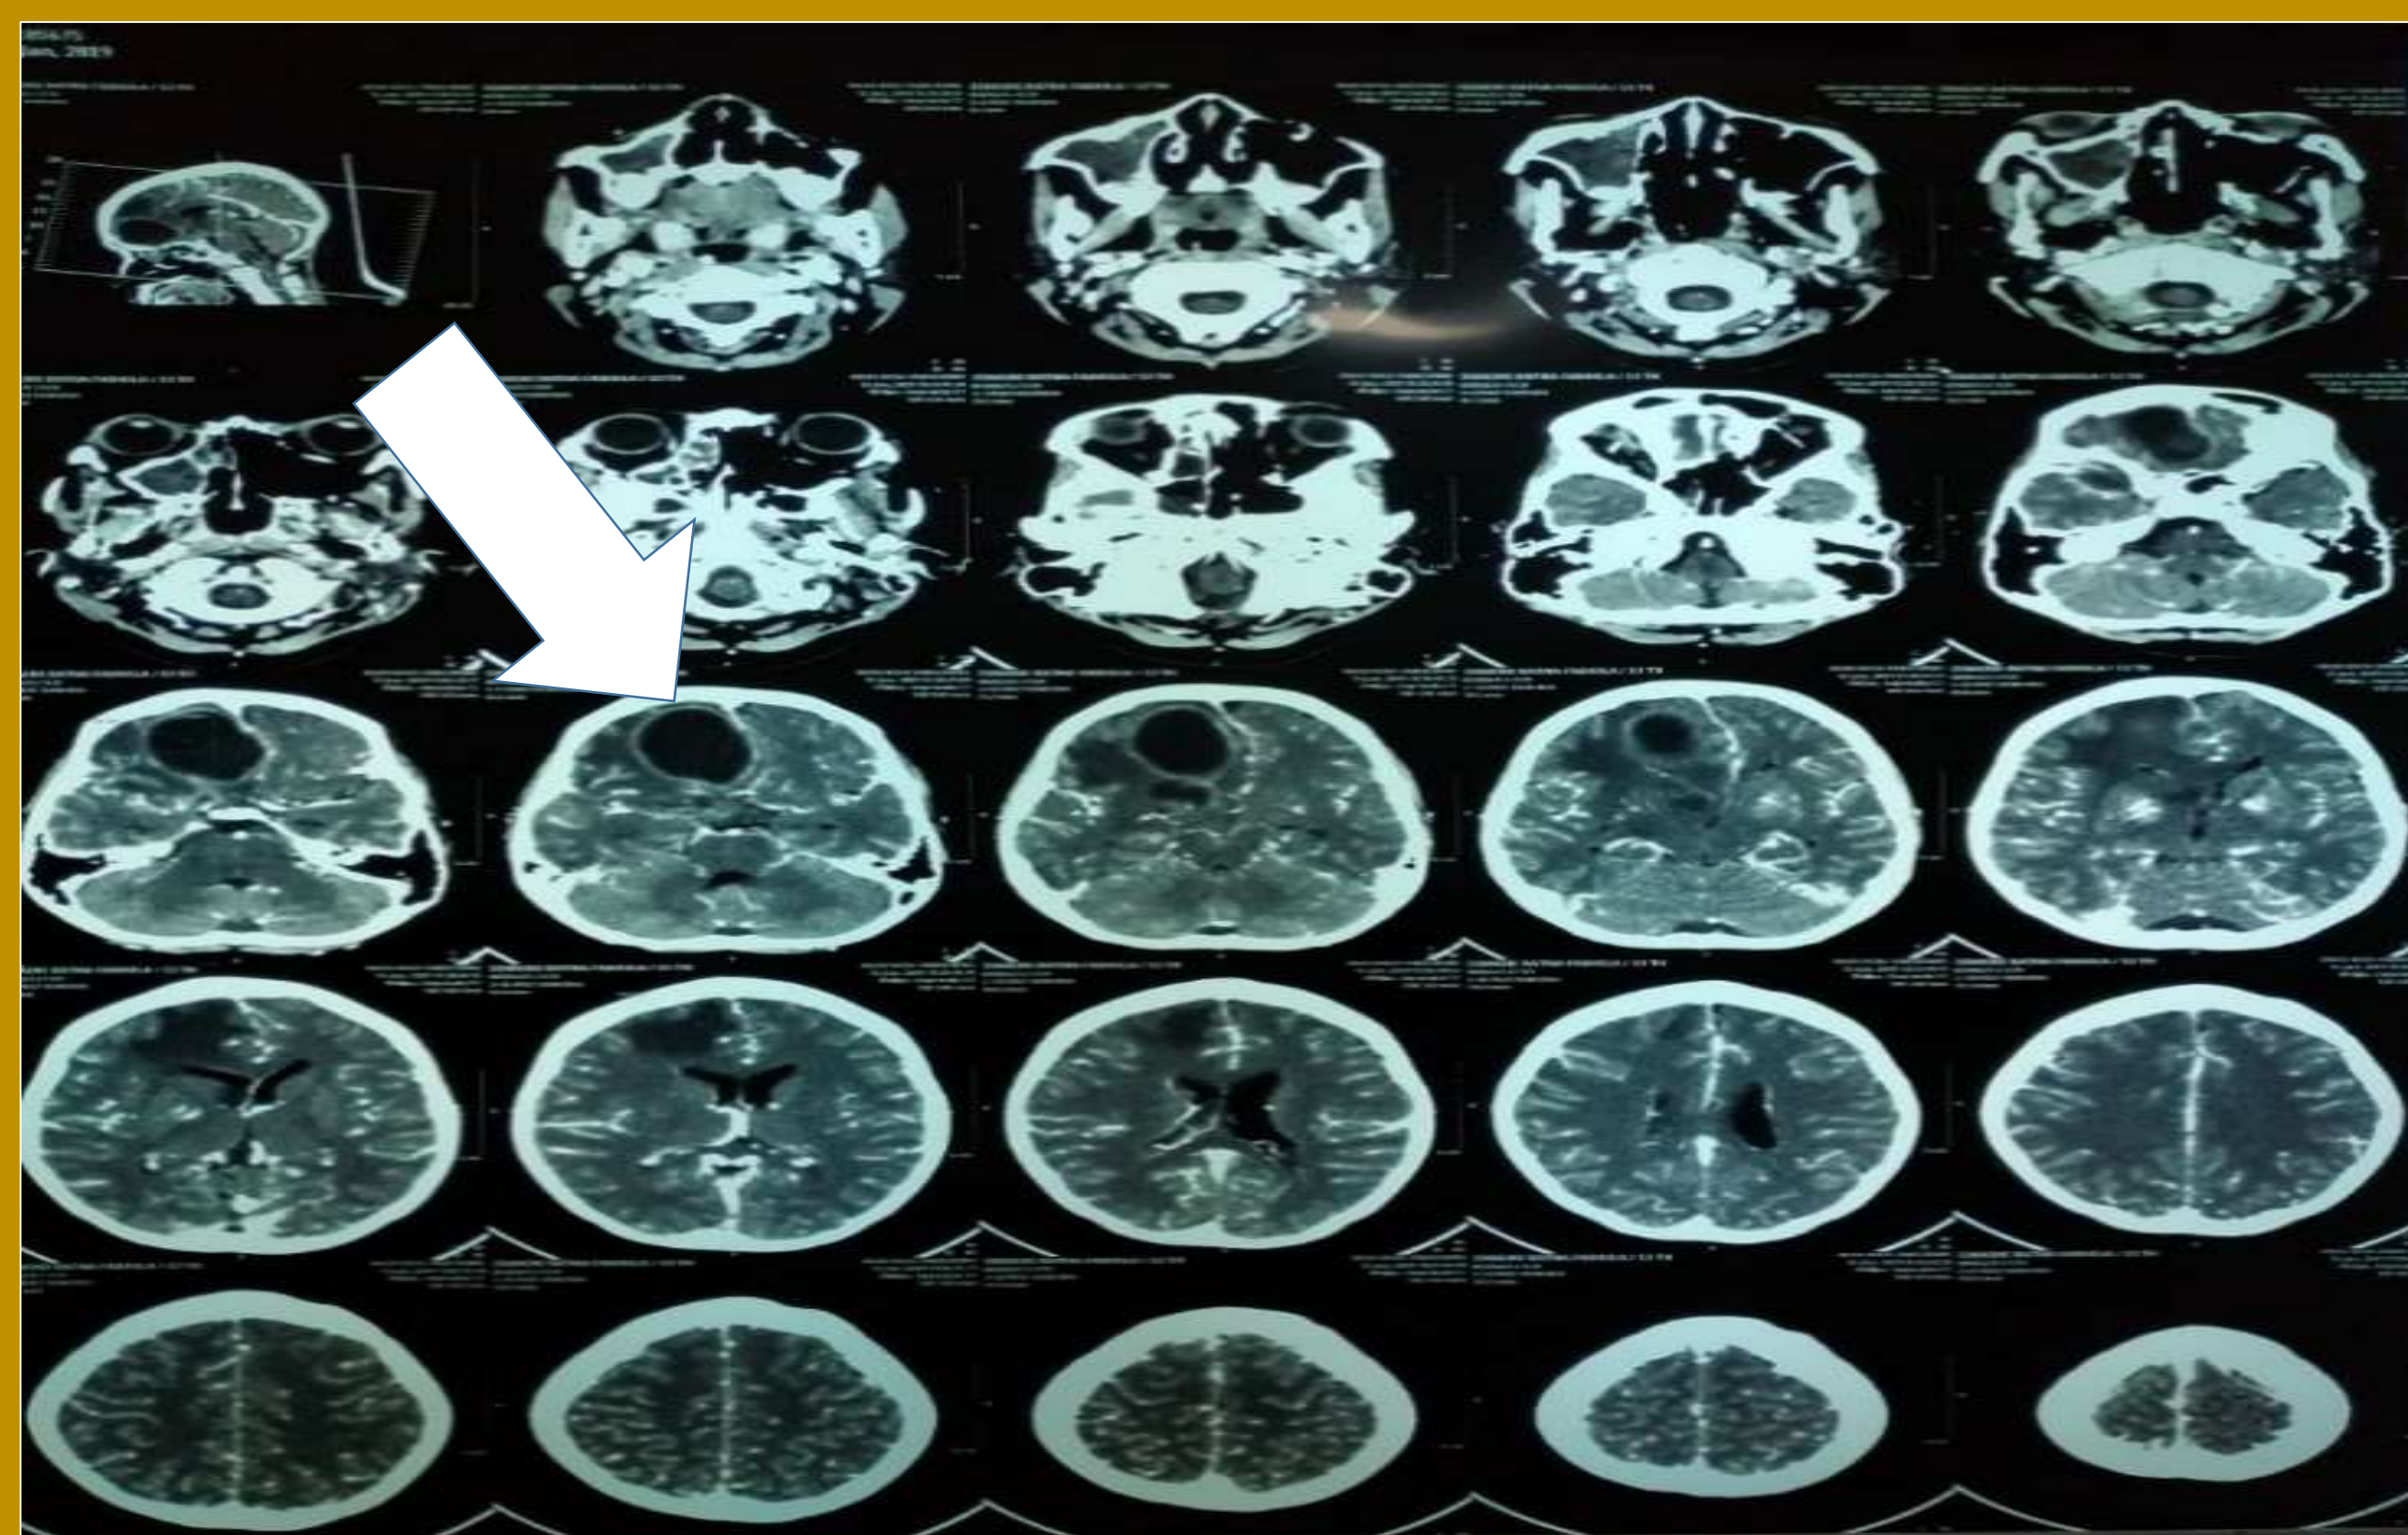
Computed Tomography (CT) showed hypo dense lesions with the presence of ring enhancement in the right frontal lobes surrounded by perifocal edema that shifted the midline to the left side.
